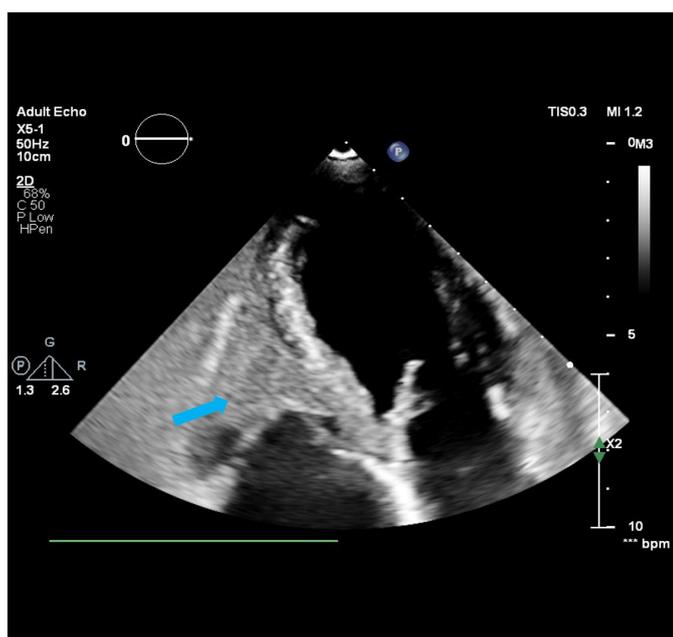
Echocardiographic examination at admission showing dilatated right ventricle with a large tumorous mass in the apex filling up to two thirds of the right ventricle, dilatated right atrium, normal left chamber and left atrium size.
